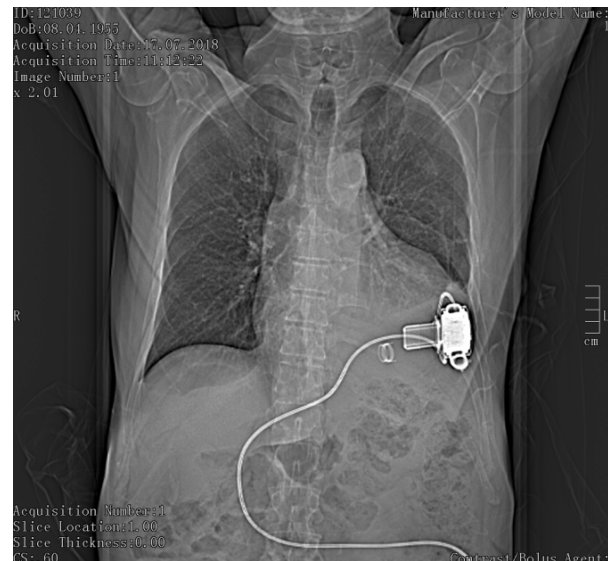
Chest X-ray: A) before, and B) after the drainage of the left pleural cavity and intensified diuretic therapy.
